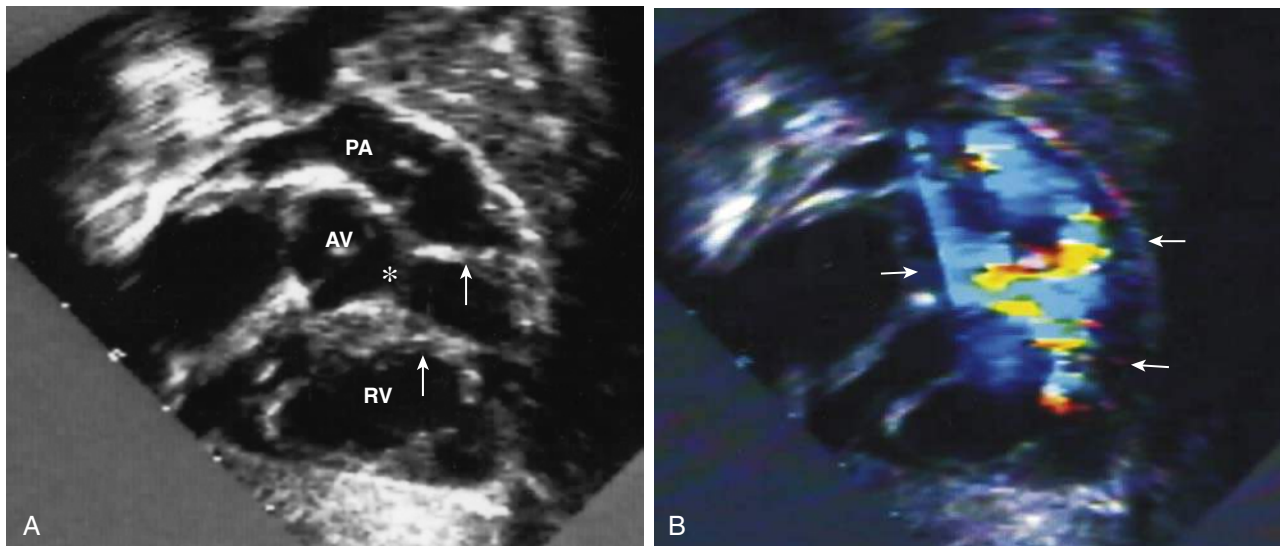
Echocardiographic images in a patient with double-chambered right ventricle and a perimembranous ventricular septal defect (VSD). Cross-sectional (A) and corresponding Doppler color flow (B) images from an oblique subcostal view, showing the right ventricular outflow tract (RVOT). A, The arrows indicate obstructing RV muscle bundles. The pulmonary valve is just proximal to the pulmonary artery (PA) label. A VSD is indicated by the asterisk, just to the right of the AV. B, Acceleration of flow through the RVOT (left-facing arrows) is seen at the locations of the obstructing RV muscle bundles and through the VSD (right-facing arrow). AV, Aortic valve; PA, pulmonary artery; RV, right ventricle.
